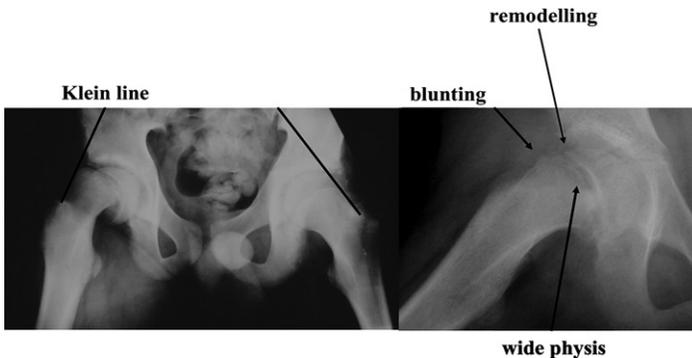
Radiographic signs of SCFE.
